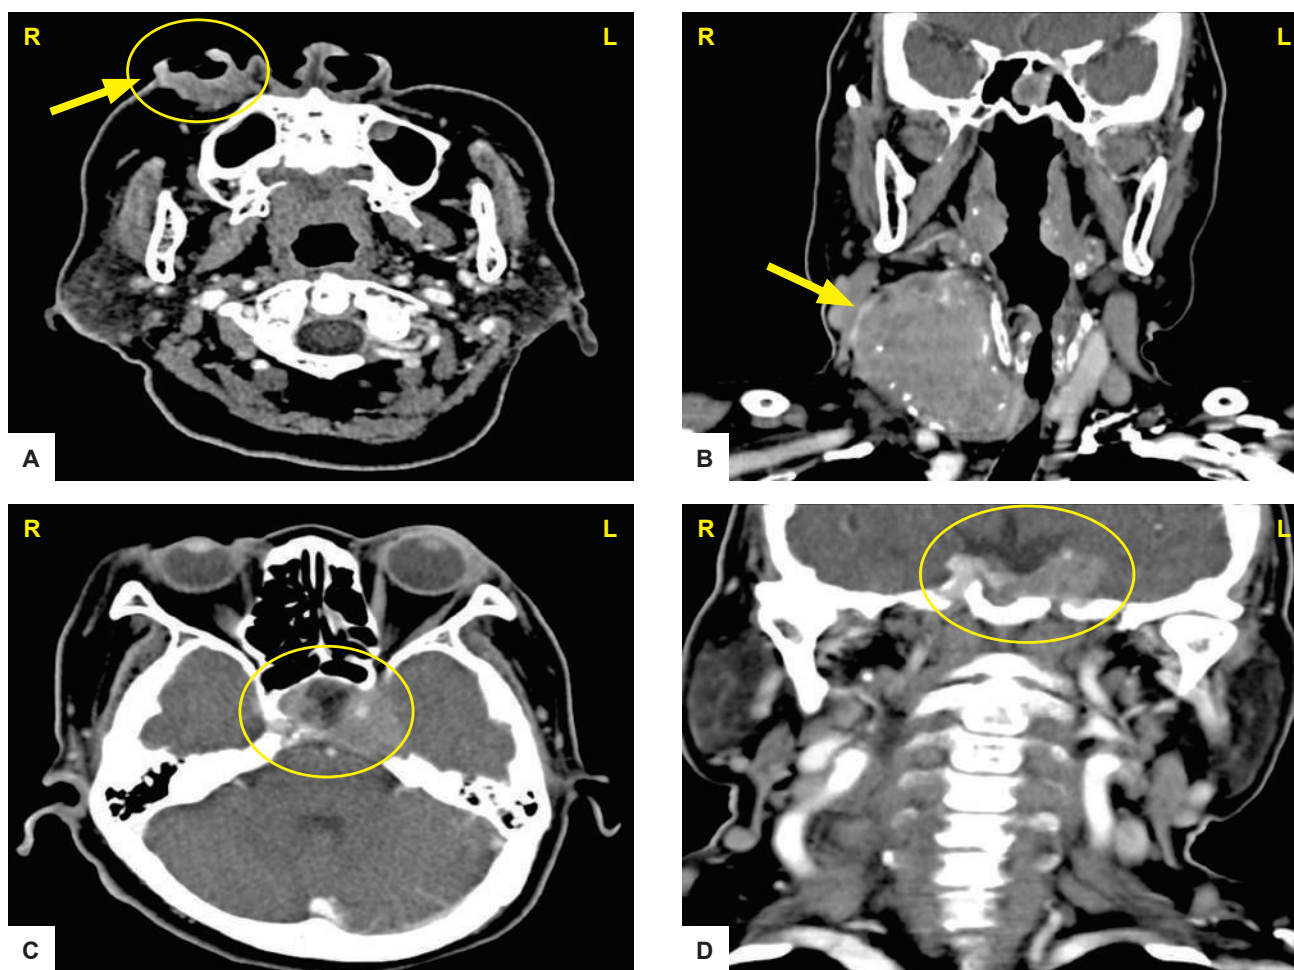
CT Scan with contrast of the head and neck. (A) Ulcerating mass (right nasolabial area); (B) 6.5x5.0x4.8 cm enhancing mass with peripheral calcifications (right thyroid lobe). Incidental left parasellar 2.3x2.9x3.6 cm enhancing mass with erosion of posterior wall of the sphenoid sinus and petrous apex in a (C) Cross-sectional view and in (D) Coronal view.
